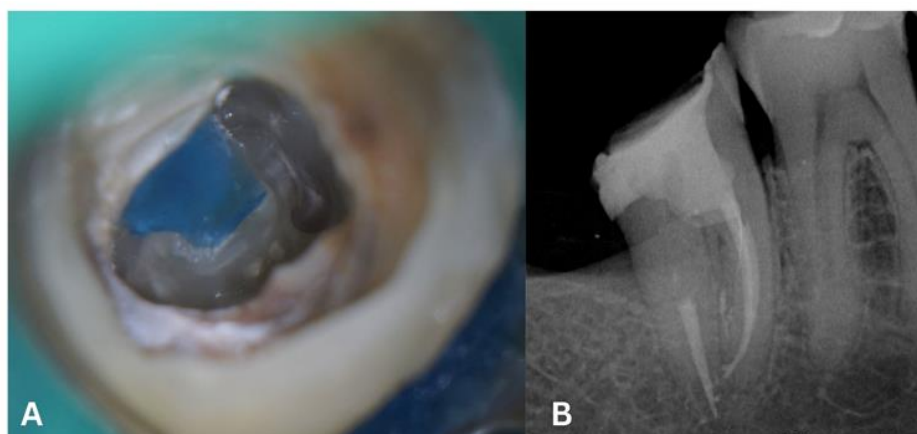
Case 3. (A) Internal isolation of the HCSC using liquid dam. (B) Post op x-ray. Perforation repair, root canal treatment and post and core placement were completed in a single session
